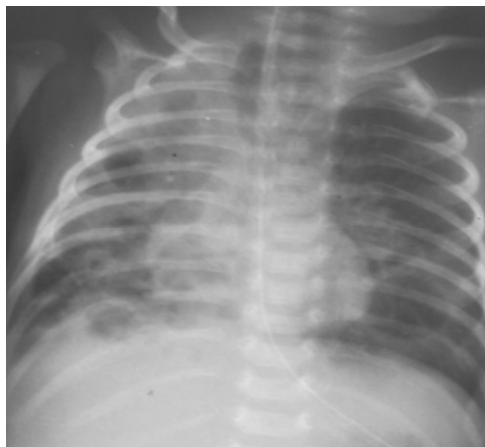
Chest radiograph after three weeks of antimicrobial therapy for *S. epidermidis* necrotizing pneumonia, showing pneumatoceles in the right lung
